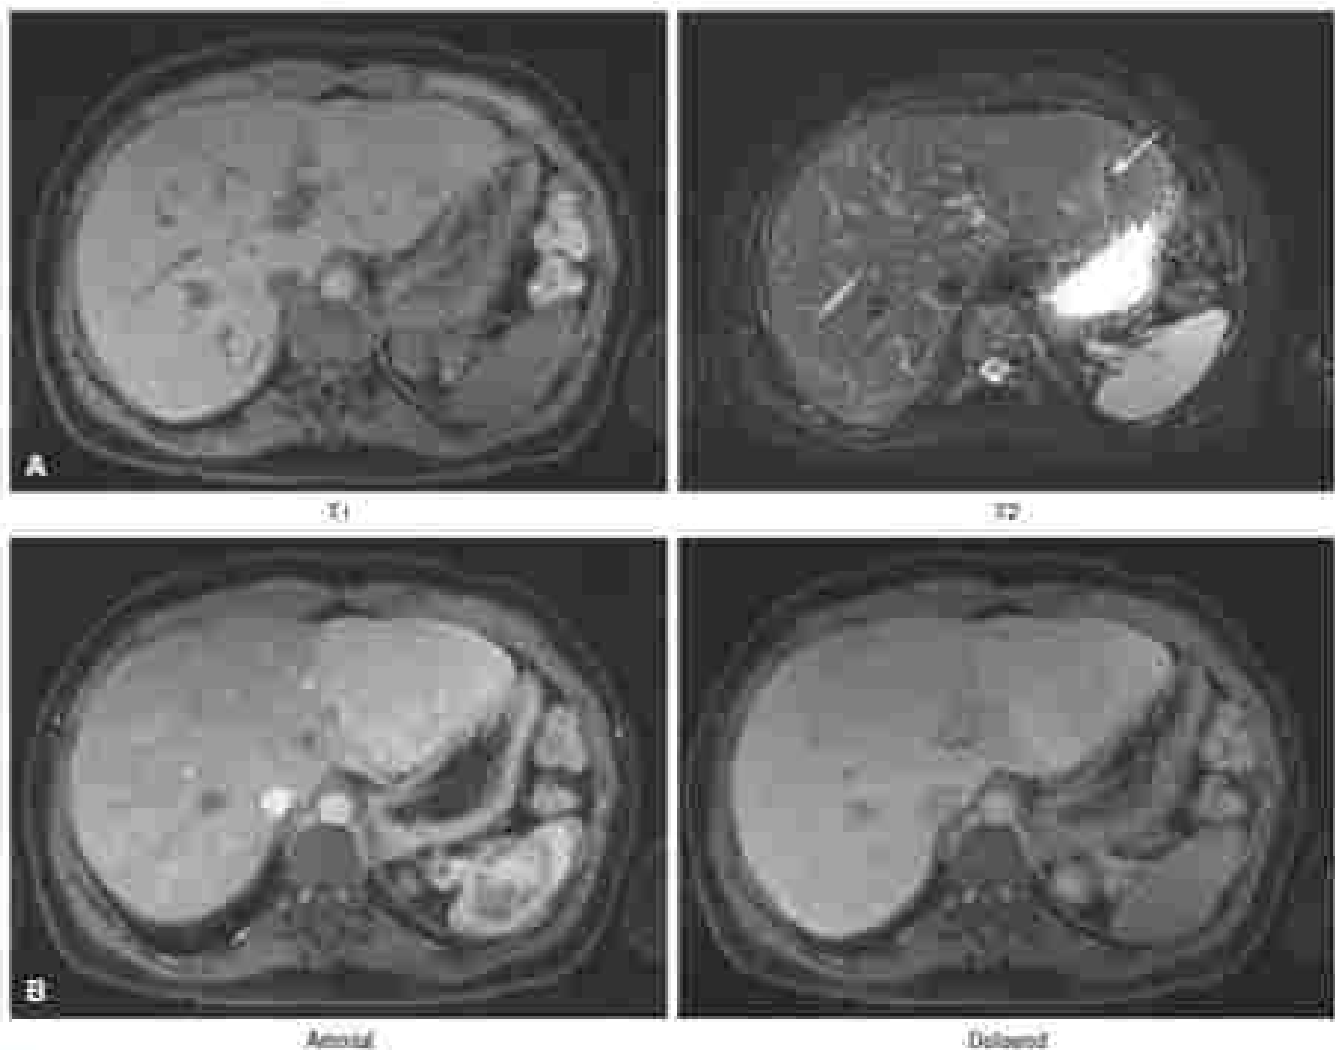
(A) Focal nodular hyperplasia (FNH) appears hyperintense throughout on T1-weighted magnetic resonance imaging, whereas on T2-weighted sequences FNH is hypointense with a hyperintense central scar (A) (arrow). (B) FNH displays early arterial enhancement with rapid washout. During the venous phase, FNH is isointense with the central scar remains enhanced.
